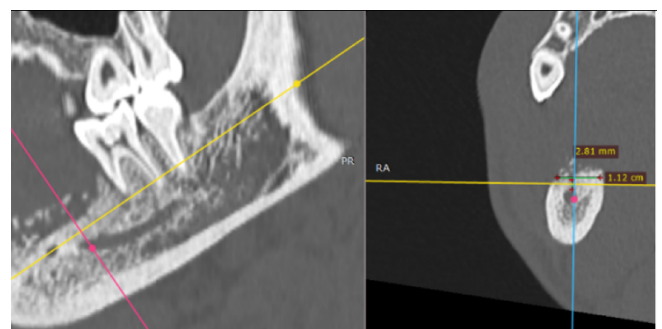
CBCT before surgery. A transversal section in the projection of the missing tooth 4.5. The width of the alveolar ridge is 7.8mm. Distance to the mandibular canal 2.81mm. before treatment 06.07.2020.
